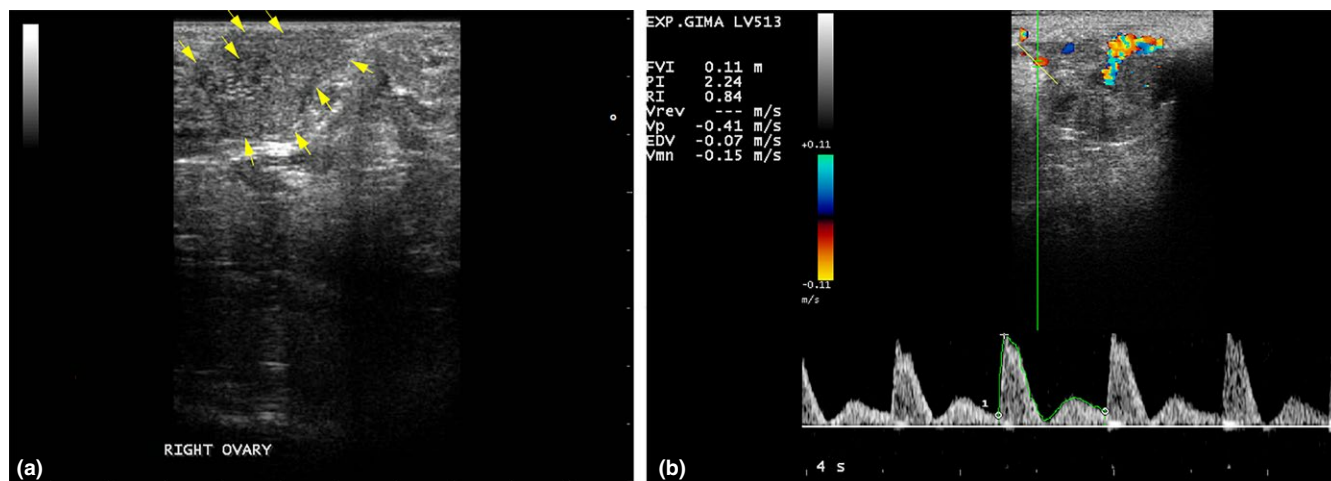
(a) Ovarian B-mode ultrasonography on Day 15 (five to six days after ovulation) of the superovulatory protocol in Santa Inês ewe, with the corpora lutea indicated by the yellow arrows. (b) Spectral Doppler ultrasonography of the ovarian artery to obtain blood flow indices (PSV, EDV, RI and PI) of superovulated ewe. EDV, end diastolic velocity; PI, pulsatility index; PSV, peak systolic velocity; RI, resistance index
